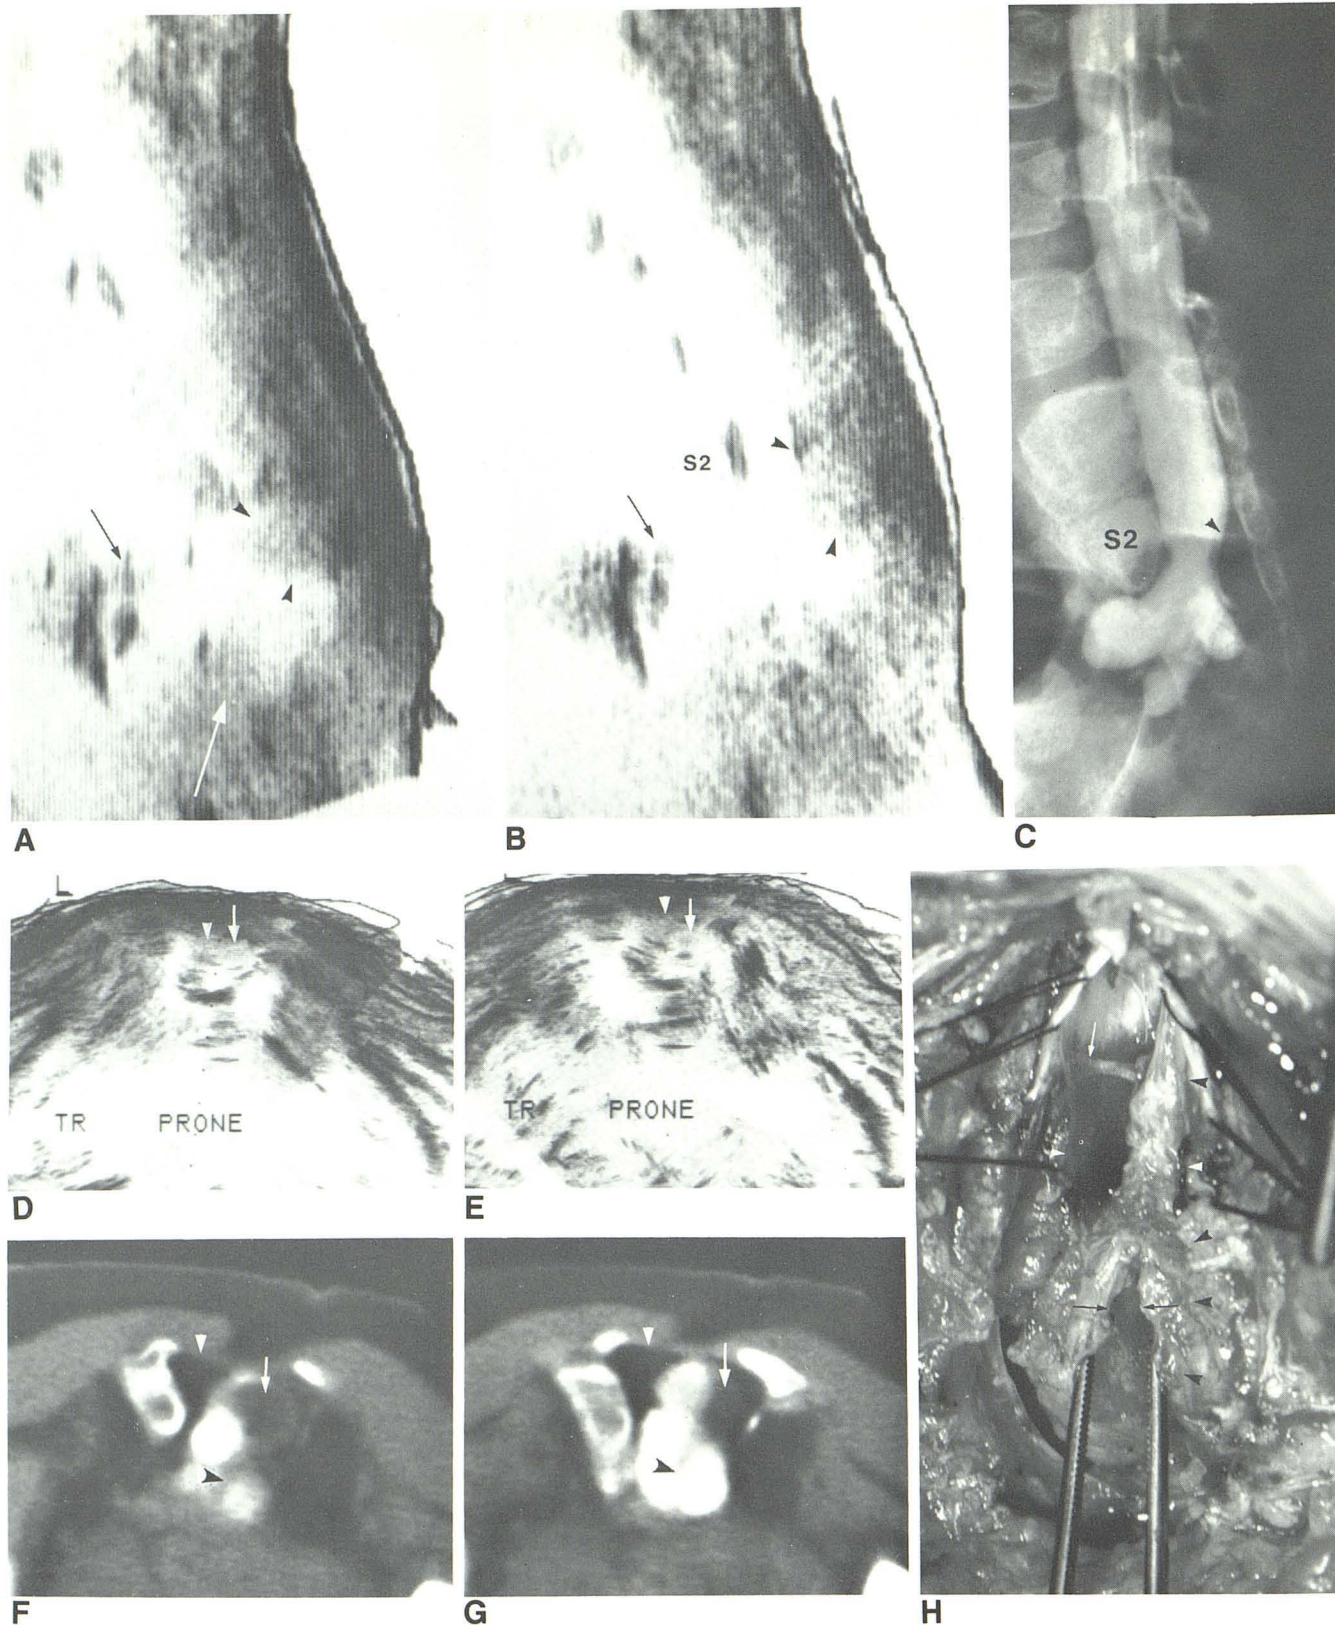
Anterior sacral meningocele with tethered cord and sacral intramedullary dermoid, 5½-year-old girl. Sagittal sonograms (A and B) and lateral water-soluble contrast myelogram (C). Focal absence of anterior and posterior sacral echoes indicates partial anterior and posterior sacral agenesis. Direct continuity of anechoic space from spinal canal through anterior sacral defect into pelvis and strong curvilinear echoes at anterior (deep) wall of space (*black arrows*) signify anterior sacral meningocele. Hyperechoic tissue (*arrowheads*) along posterior wall of sacral spinal canal corresponds to large extraarachnoid fat pad observed surgically. Round homogeneous echogenicity (*white arrow*) at lower end of spinal canal corresponds to wholly intracanalicular dermoid.
